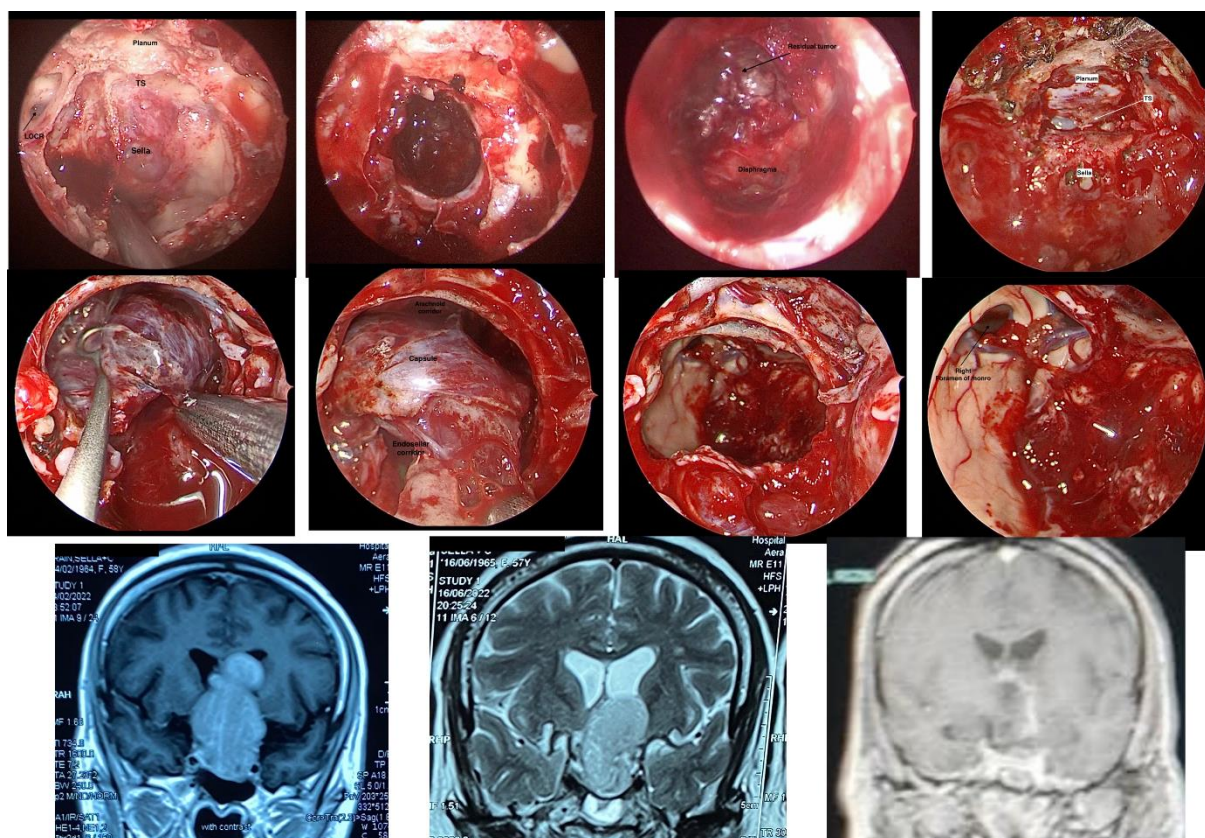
A case we did a 2 staged endonasal approaches for, the 1st using the standard endosellar approach and the second using the extended transtuberculum transplanum approach. in the 1st surgery we exposed the sella, tuberculum, planum and the parasellar recesses but we only worked through the sella and we did good debulking of the lesion which was firm invading the diaphragma sella and extending to the suprasellar cisterns (a, b, c) we left this part of the tumor for a second stage surgery, repeated MRI after 3 months showed significant descent into the resection cavity. we went again using the endonasal approach after drilling of the tuberculum and planum (d) we opened the dura over the tuberculum, and we did extracapsular dissection of the tumor from the neurovascular structures using the arachnoid corridor and using both corridors the endosellar and the arachnoid corridor we completed excision of the tumor (e, f). at the end of tumor excision, we can see the invaded floor of 3rd ventricle, both foramina of Monroe and the lateral ventricles (g, h), MRI showing the tumor before the 1st surgery (i), 3 months after the 1st surgery (j) and 5 days after 2nd surgery showing GTR of the tumor (k)
